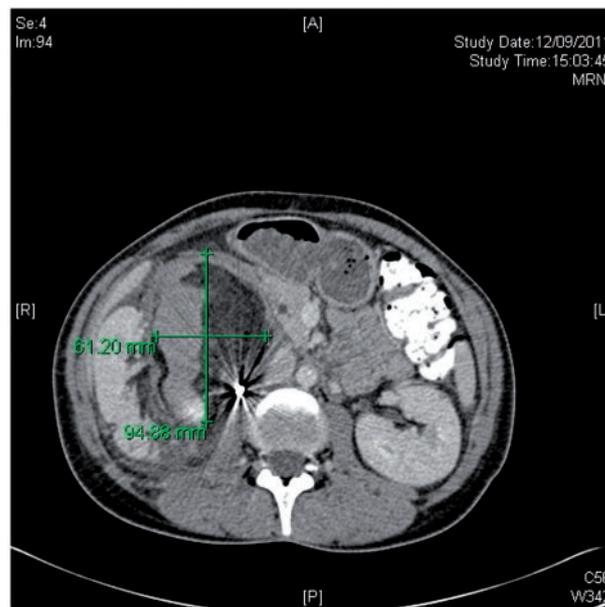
CT scan after the procedure shows grossly unchanged haemorrhagic AML. There is some infarction of the posterior hilar lip of the interpolar right kidney in keeping with recent embolization. No evidence of active bleeding.
